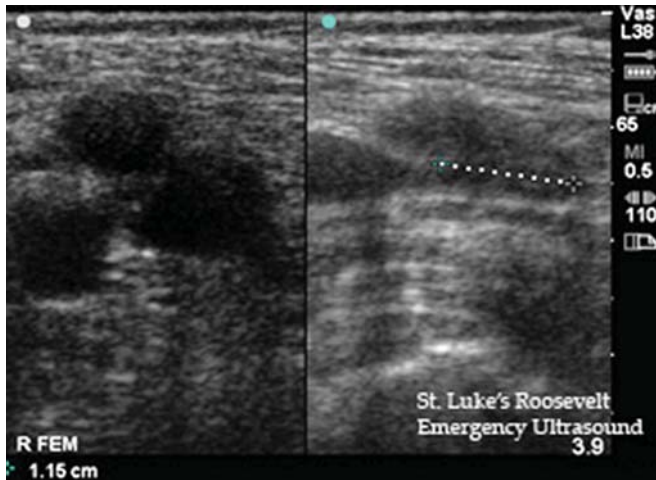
Ultrasound imaging for deep vein thrombosis
